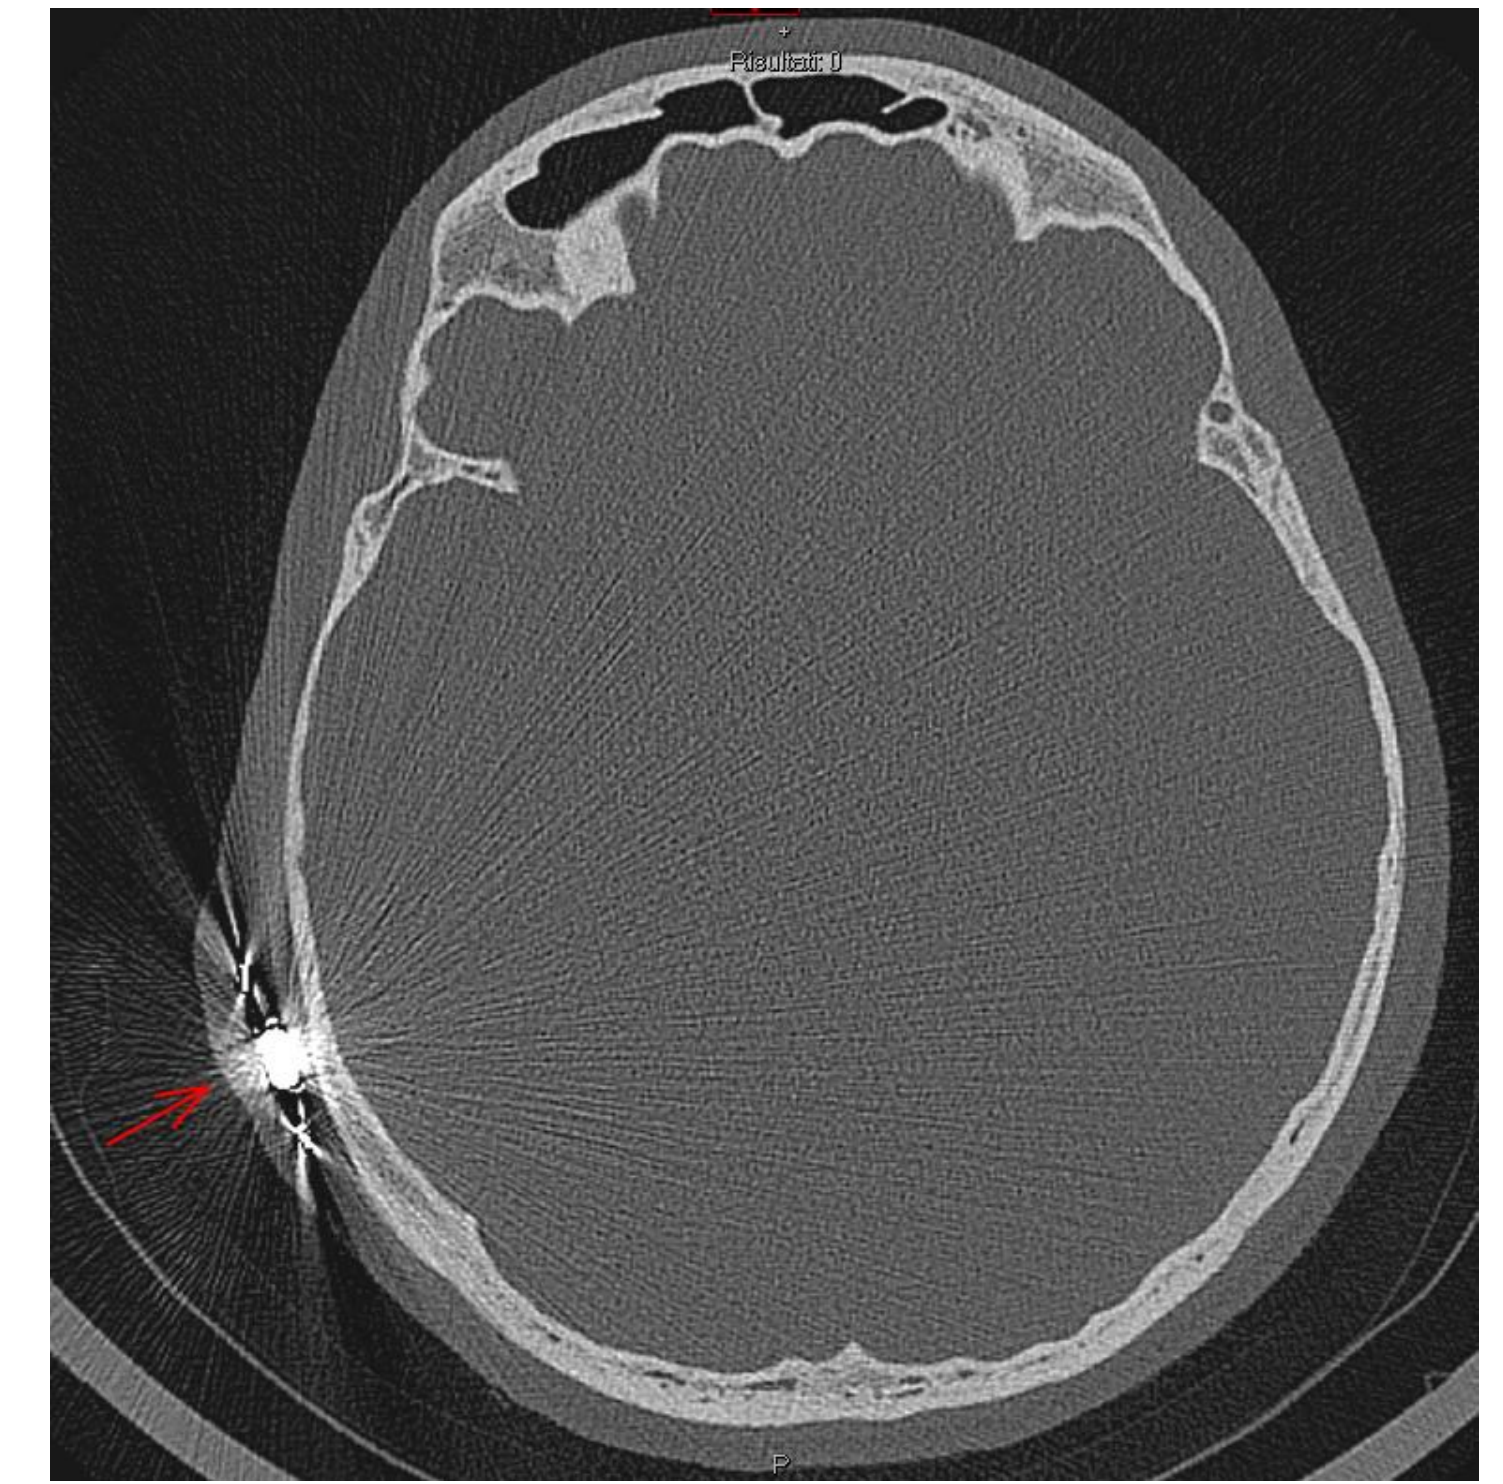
CT scan before the removal of the cochlear implant: tissue swelling that causes deformation near of the receiver (red arrow)
